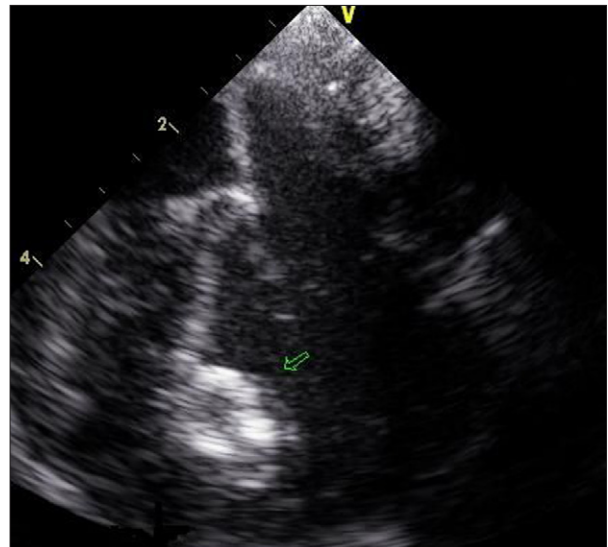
Muscular ventricular septal defect closure with one disc expanded – transoesophageal echocardiography (TEE) image.
